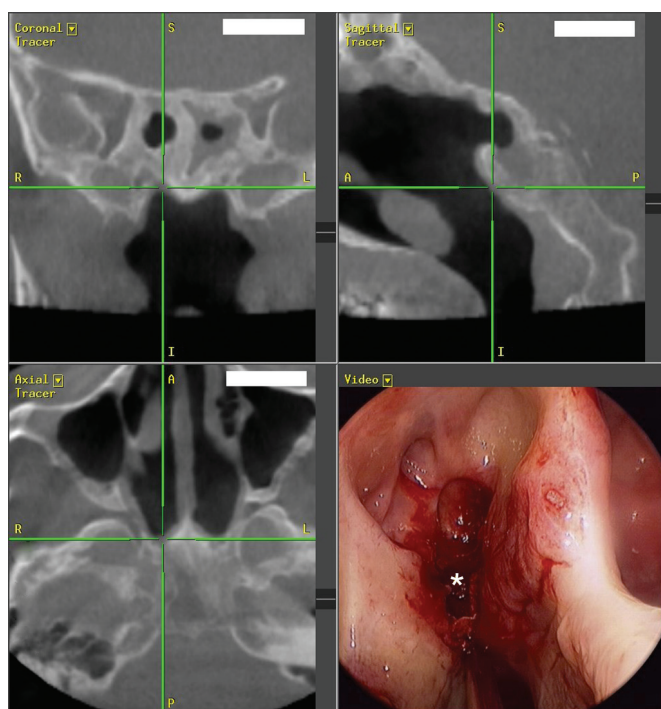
Osteitis of the sphenoid sinuses. Computed tomography images demonstrate the irregular bony thickening that is characteristic of bony osteitis. The overlying mucosal inflammation and narrowing of the sinus cavity as seen on the endoscopic view of the sphenoid sinus are frequently associated with underlying osteitis (asterisk = surgically opened ostium into the sphenoid sinus).
